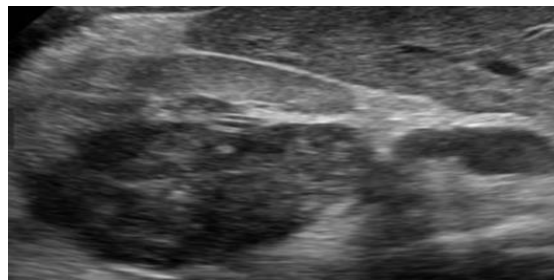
2D abdominal ultrasound (transverse view) revealed a large irregular mass in the upper pole of right kidney, measured (8.5 X 7.5 cm) with heterogeneous echopattern.
